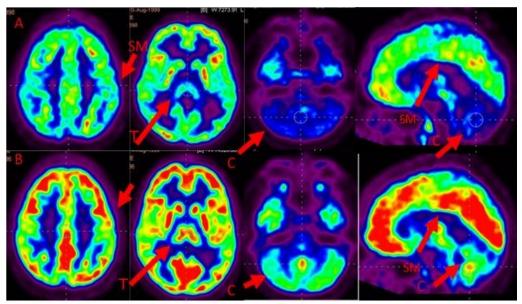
Representative Transaxial section of the sensory ataxia. (A) FDG PET/CT image before cellular therapy metabolism in bilateral sensory motor cortex (SM), thalamus (T) and cerebellum(C) (B) FDG PET/CT image of six-months after cellular therapy showed improved metabolism in bilateral sensory motor cortex (SM), thalamus (T) and cerebellum (C).
